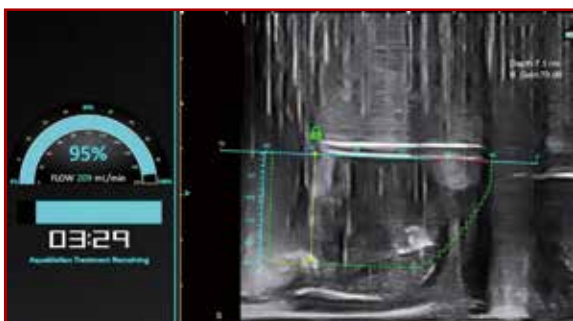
Real-time ultrasound showing hydrodissection of prostate in Aquablation (Personal collection of Dr Peter KF Chiu)
